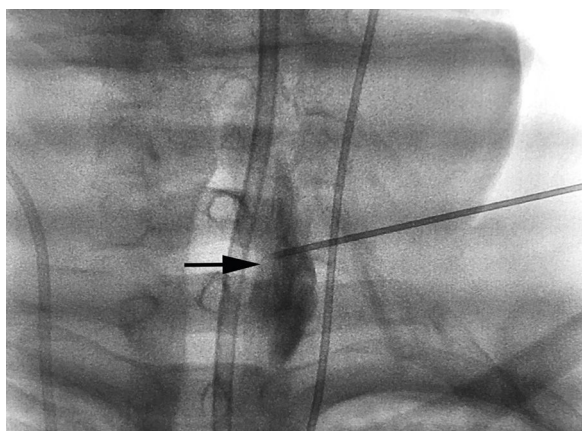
Block technique under X-ray imaging.
